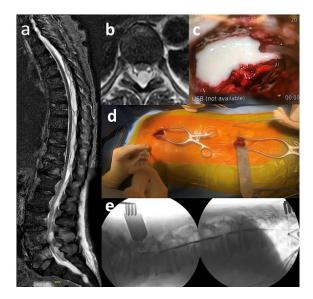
A) MRI sagittal section in STIR sequence of the spine where the extension of the abscess is evidenced. B) Axial section in T2 sequence at T8-T9 level, site of maximum cord compression. C) Purulent material in decompression sites. D and E) Epidural flushing with a catheter through decompression site, answering their communication with contrast medium.
